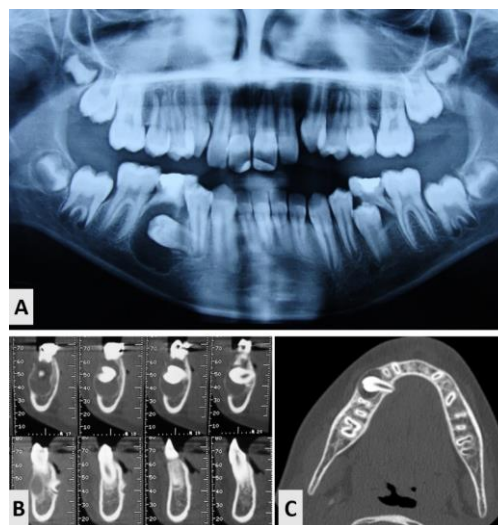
Radiographic examination; (A) Preoperative panoramic radiograph showed a large radiolucent area associated with a developing 45; (B, C) CBCT images: cross-sectional and axial slices
